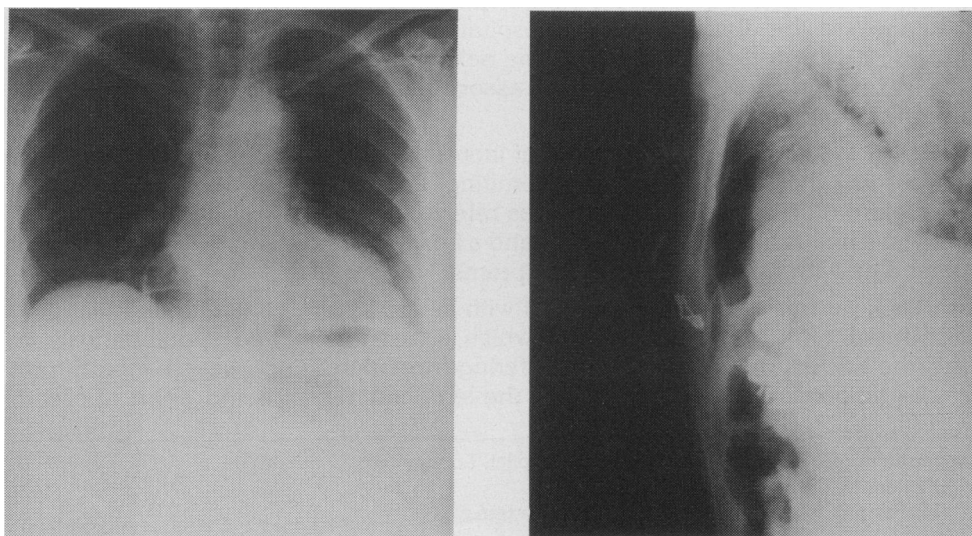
Fig (a) and (b). Anteroposterior and lateral chest X-rays showing air-filled loops of bowel in the anterior mediastinum.
